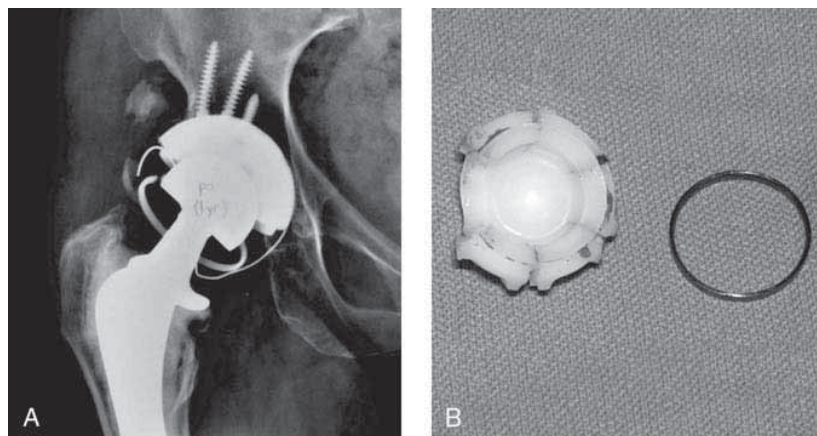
A, AP radiograph of the hip demonstrating failure of the constrained liner. B, The locking mechanism (ring) of the constrained liner has broken.
